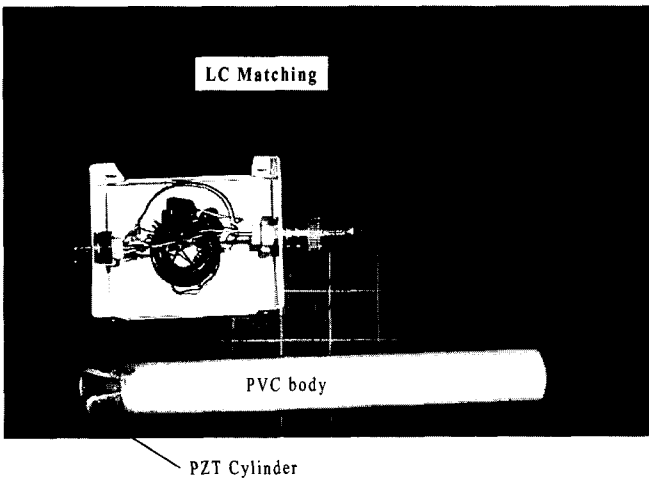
A picture of the single-element intracavitary ultrasound applicator.
